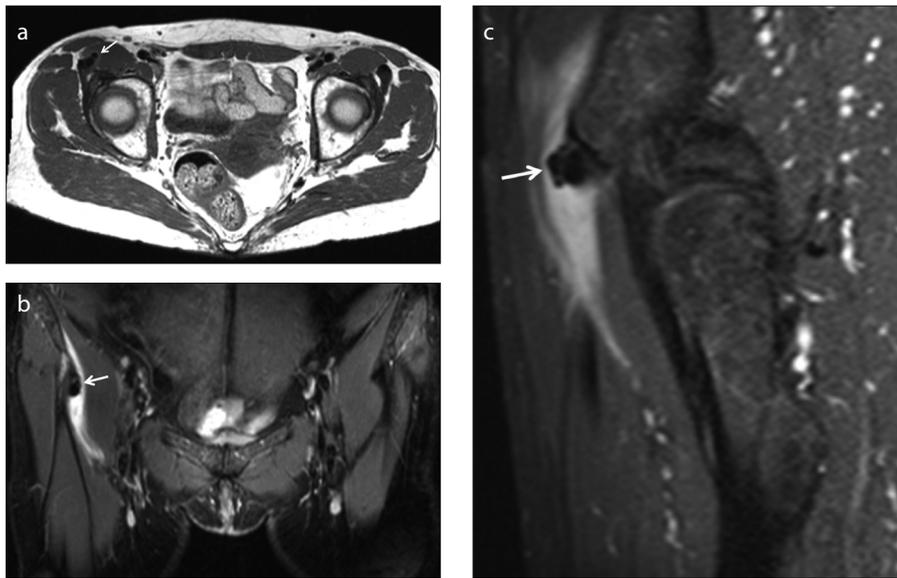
a–c. A 55-year-old female with right side pain lasting for three months. The axial T1-weighted (a), coronal STIR (b), and sagittal fat suppressed proton density weighted (c) images show calcification within the musculotendinous junction of the straight head of the right rectus femoris (arrow in a–c) with surrounding soft tissue edema.
